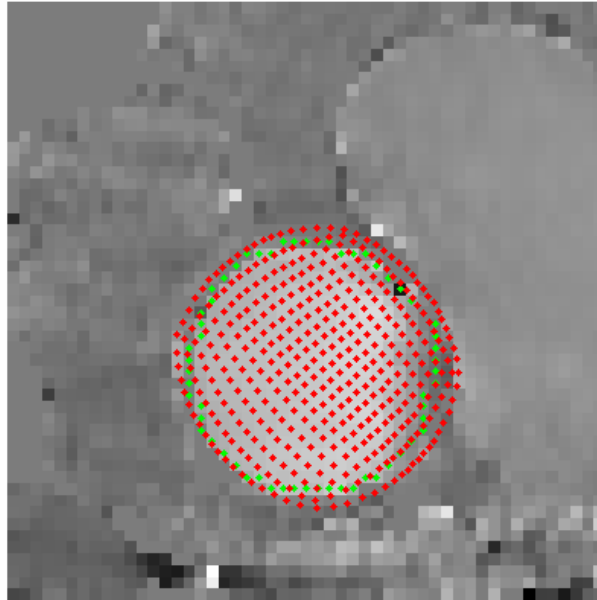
PC-MRI inlet velocity distribution was transformed to the CFD inlet section: the red points are the cell's centers of the mesh on the inlet section of the CFD model; green points are the boundary segmented from the modulus image; the upper image is the modulus image; the lower image is the phase image where the pixels outside the lumen are forced to be zero.
